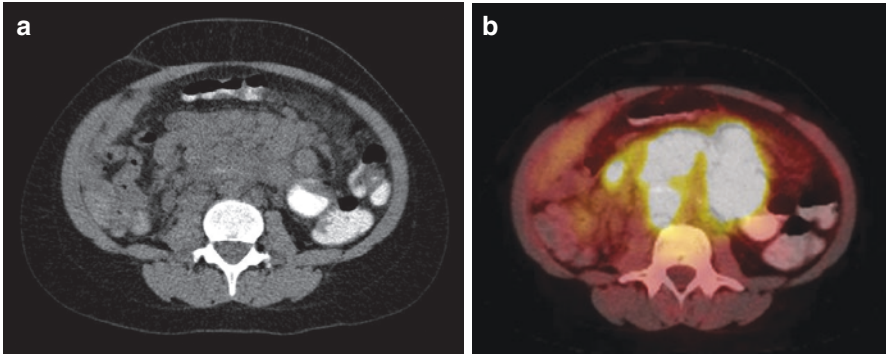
Noncontrast CT (a) and fused FDG-PET CT (b) showing FDG-avid mesenteric and retroperitoneal lymphadenopathy in a patient with PTLD
